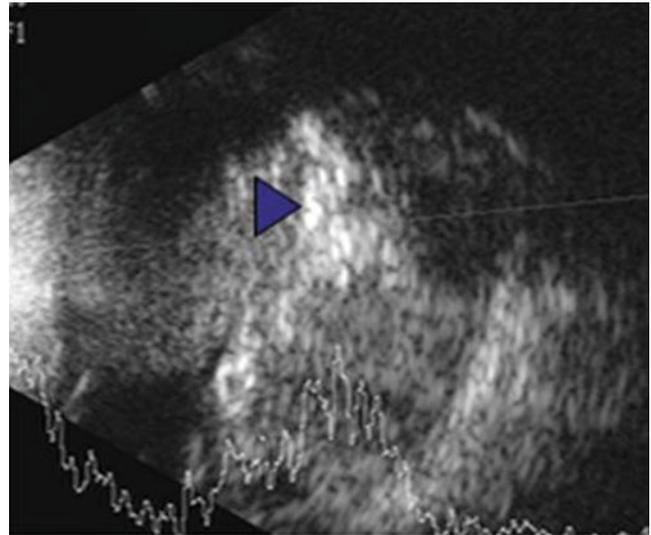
Ultrasonography revealed mass lesion in the posterior segment along with calcification (*arrow*)
